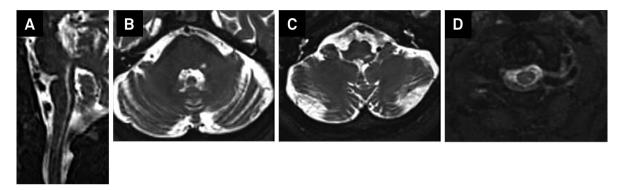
MRI of trigeminal zoster. (A) Sagittal oblique T2 SPACE image reconstructed from the axial dataset shows abnormal longitudinal hyperintense signal along the expected course of the nucleus of the spinal tract of the trigeminal nerve extending from the lower pons into the dorsal upper cervical cord. (B, C, and D) Axial T2 SPACE images show abnormal hyperintense signal in the expected location of the nucleus in the dorsal pons (B), medulla (C), and upper cervical cord (D) on the left.
